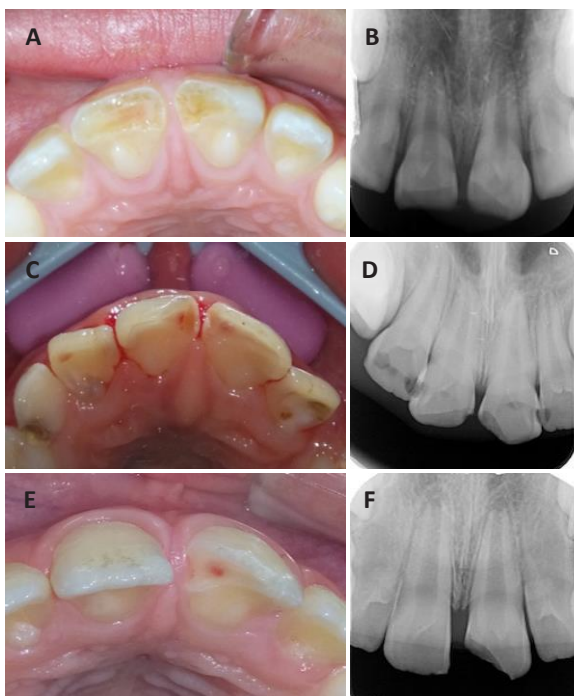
A) Clinical view of the crown fractures and B) the periapical radiograph of Case I. C) Clinical examination of the upper incisors and D) the periapical radiograph shows decayed and fractured teeth of Case II. E) Clinical examination of the crown fractures and F) radiograph of #21 showing an open apex with 3/4 root development of Case III.
